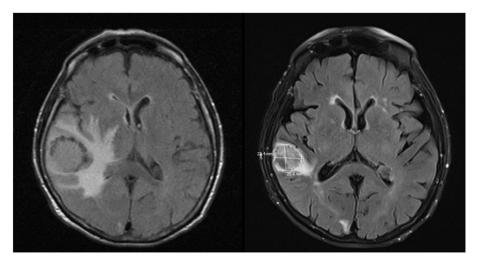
MRI: Before radiotherapy. A.  $3 \times 4$  cm right temporo-parietal metastatic lesion with surrounding vasogenic edema, mass effect and midline shift, approximately 0.5 cm shift to the left. B. Post radiotherapy image showing interval decrease in size in the right temporo-parietal lesion now measuring  $2.2 \times 2.0$  cm with marked decrease in the surrounding vasogenic edema, resolution of the mass-effect on the lateral ventricles and the midline shift.
